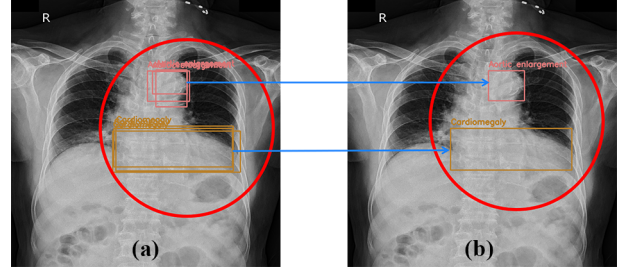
An implementation of the WBF algorithm on an original chest x-ray image in a dataset. (a) the original one presented two lesion areas annotated by overlapped bounding boxes, and (b) the one described two lesion regions without overlapped bounding boxes after applying the WBF algorithm.
